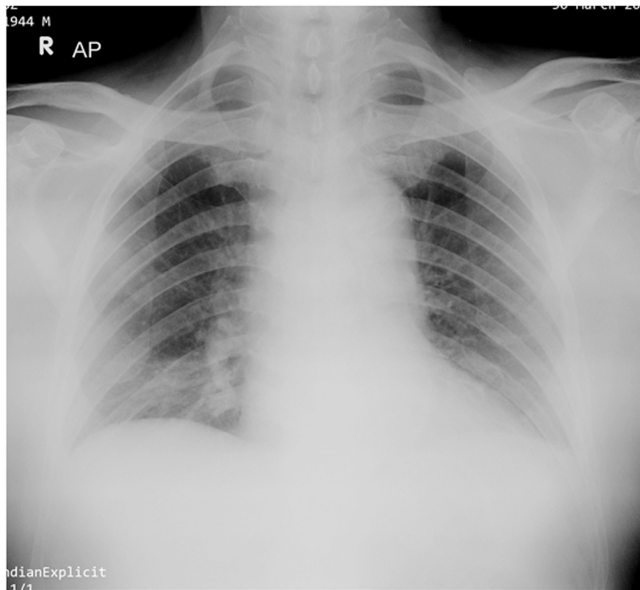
Chest radiograph of a 77 year old male. hazy and reticular densities in the right paracardiac area, suggestive of pneumonia.
